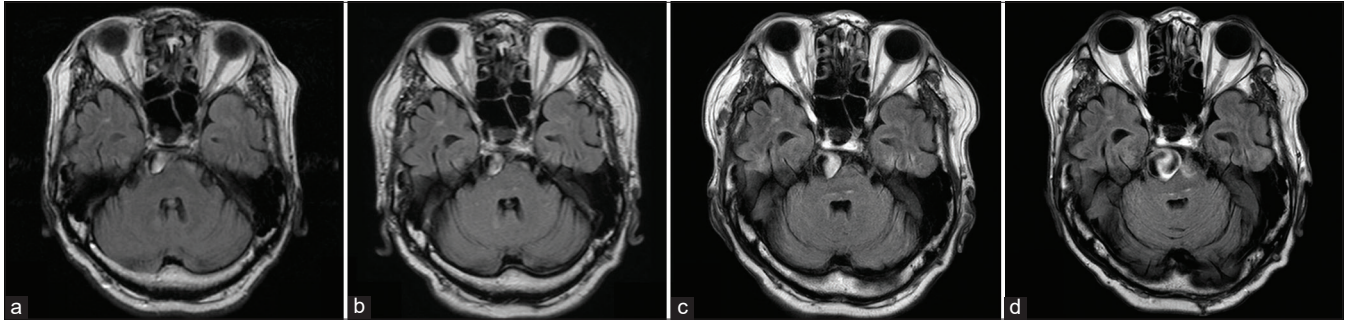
Time course images of fluid-attenuated inversion recovery. Magnetic resonance imaging on admission (a), 2 years later (b), 4 years later (c), and 6 years later (d) slow dilatation of the basilar artery.
